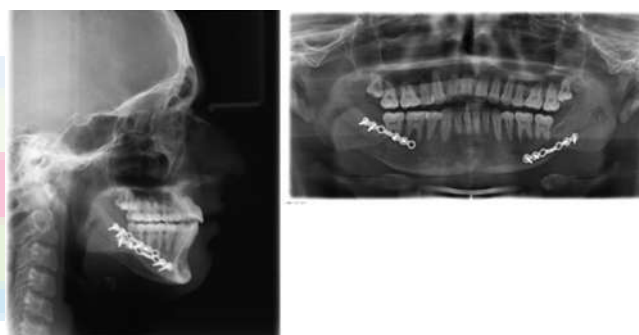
Posttreatment radiographs of case report 2
